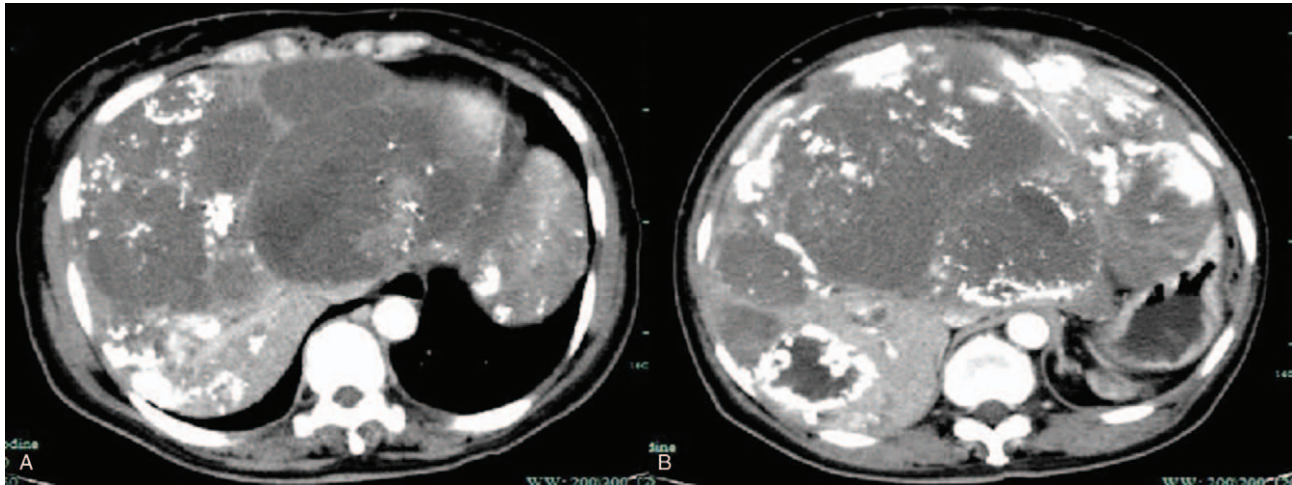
CT scan demonstrating intrahepatic nodules significantly enhanced after twice TACE treatment.
